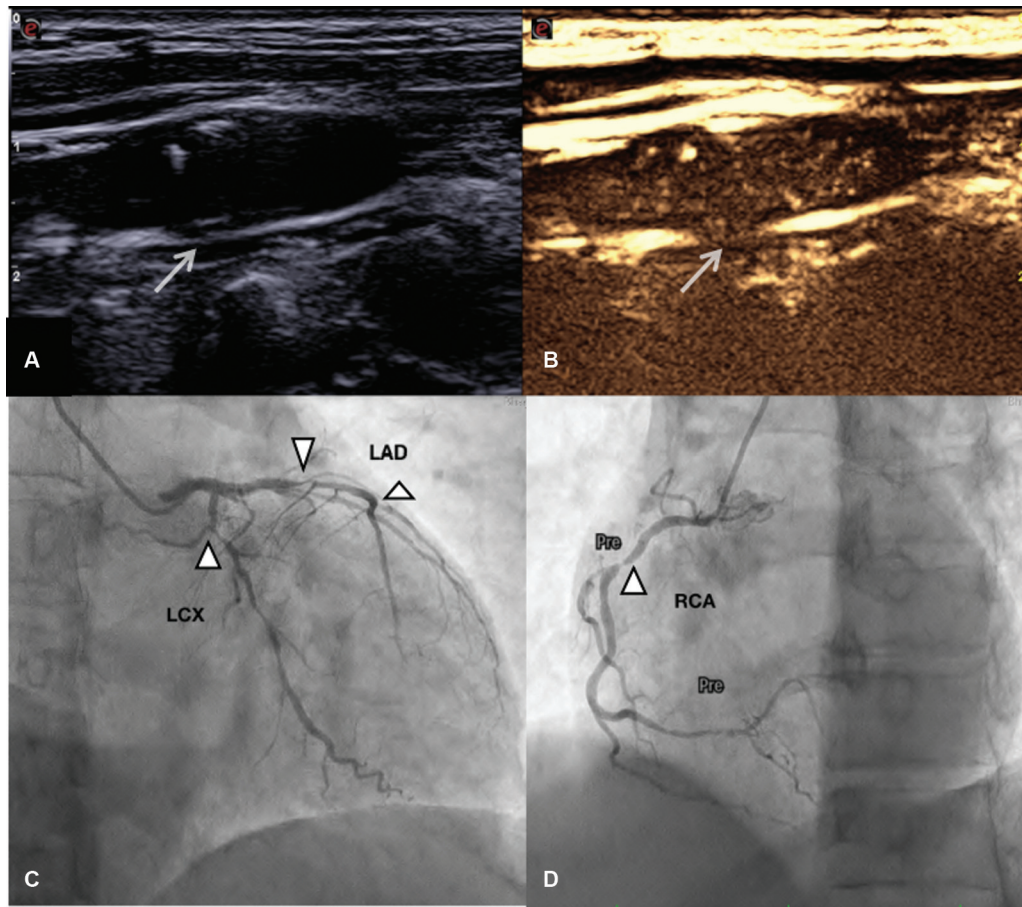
Grayscale (A) and contrast-enhanced ultrasound (CEUS) images (B) from another patient in the case group. (A) Nonobstructive predominantly hypoechoic carotid plaque having few foci of calcification. (B) Homogeneous contrast enhancement. Coronary angiography (C and D) revealed multifocal severe stenosis (marked by arrowheads) involving left anterior descending artery (LAD), left circumflex coronary artery (LCX), as well as right coronary artery (RCA).
